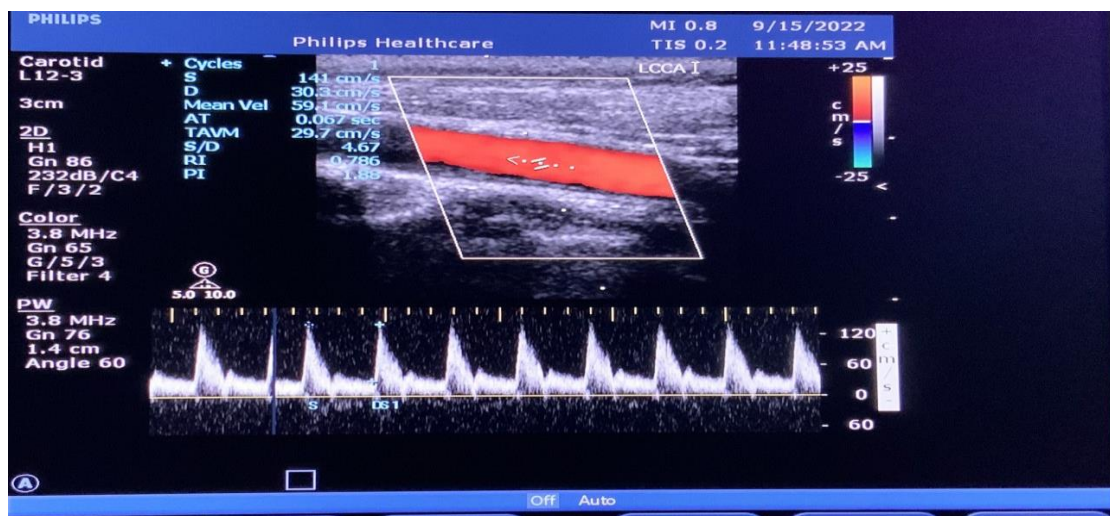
Doppler flow imaging and Spectral analysis of common carotid artery.
